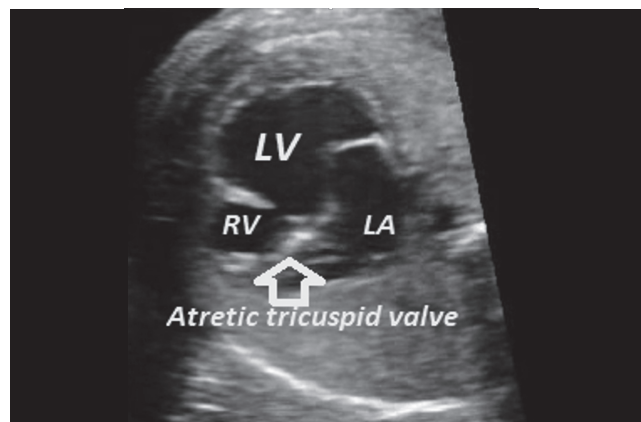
The fetal cardiac ultrasound in the axial view of the heart shows an atretic tricuspid valve, a small and hypoplastic RV, and a single-ventricle LV morphology.
